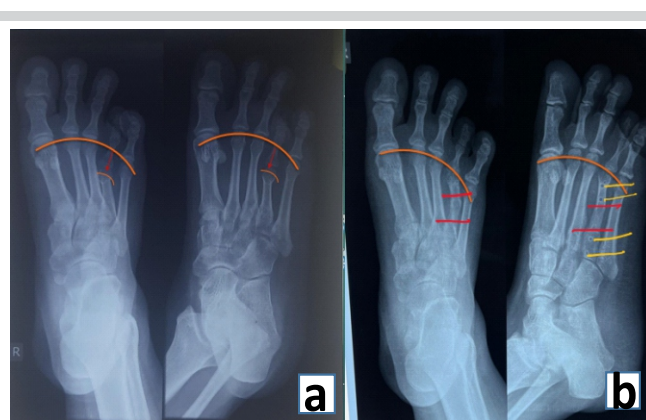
X-ray after 6 months. (a) Right foot anterior posterior view and oblique view with metatarsal lengthening of 2 cm. (b) Right foot anterior posterior view and oblique view with arch of parabola achieved with metatarsal lengthening of 2 cm.
